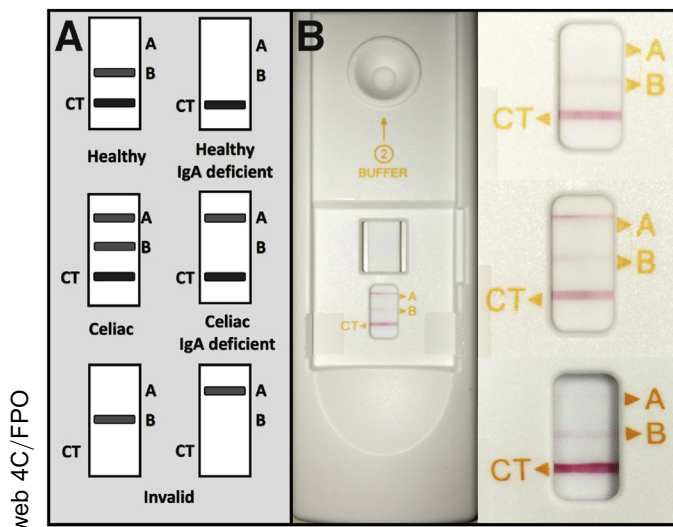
Simtomax POCT. (A) Instructions to read test results (adapted from the manufacturer's instructions leaflet). Band A is for DGP antibodies detection, Band B is for total IgA (presence of a visible line indicates normal IgA levels), and Band CT is a control band (absence of a visible line indicates invalid result). (B) Example of POCT tests with representative results of negative (above), positive (middle), and weakly positive (below) POCT in 3 subjects with normal IgA levels.
